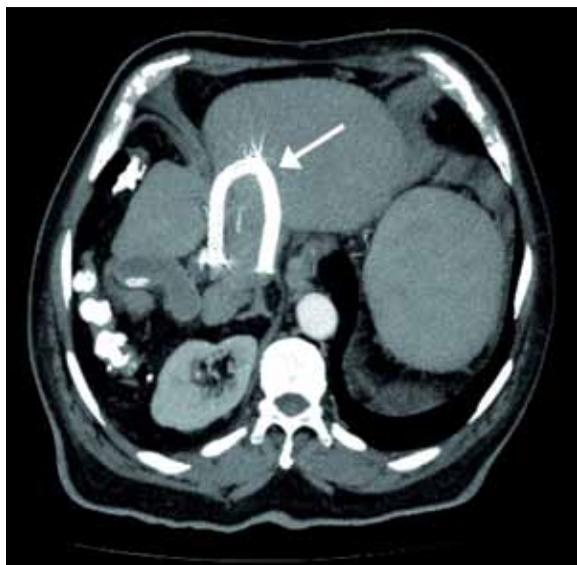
CT scan of a portosystemic shunt tract that was created by introducing a self-expanding stent graft (Fluency, Bard, Karlsruhe, Germany) and a self-expanding stent (Eluminexx, Bard, Karlsruhe, Germany) (arrow).
